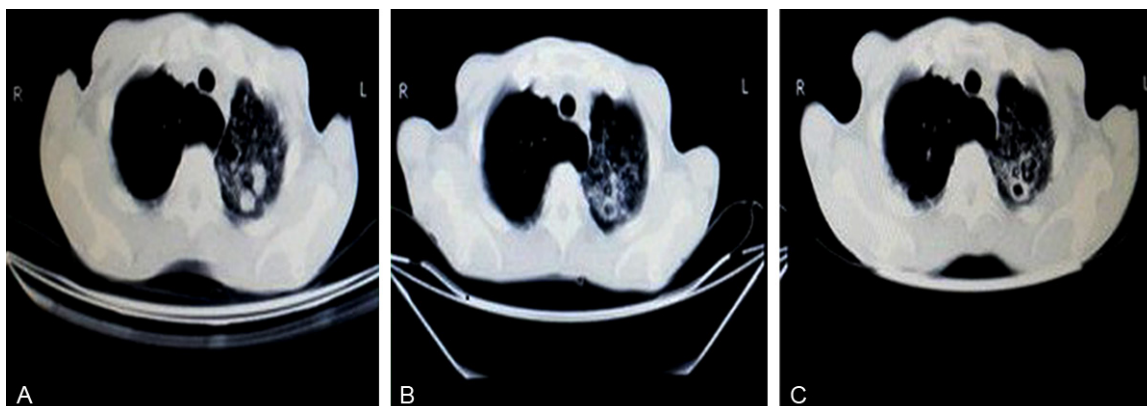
Chest computed tomographies (CT). A: Upon second admission, the diagnosis of invasive pulmonary aspergillosis (IPA): Multiple lesions were present in left lungs, including: cavity, bronchiolitis associated with thickened edbronchial walls; B: After 45 mg/day prednisone treatment in second admission; C: lesions were relapse in left lobe of third-time admission.
